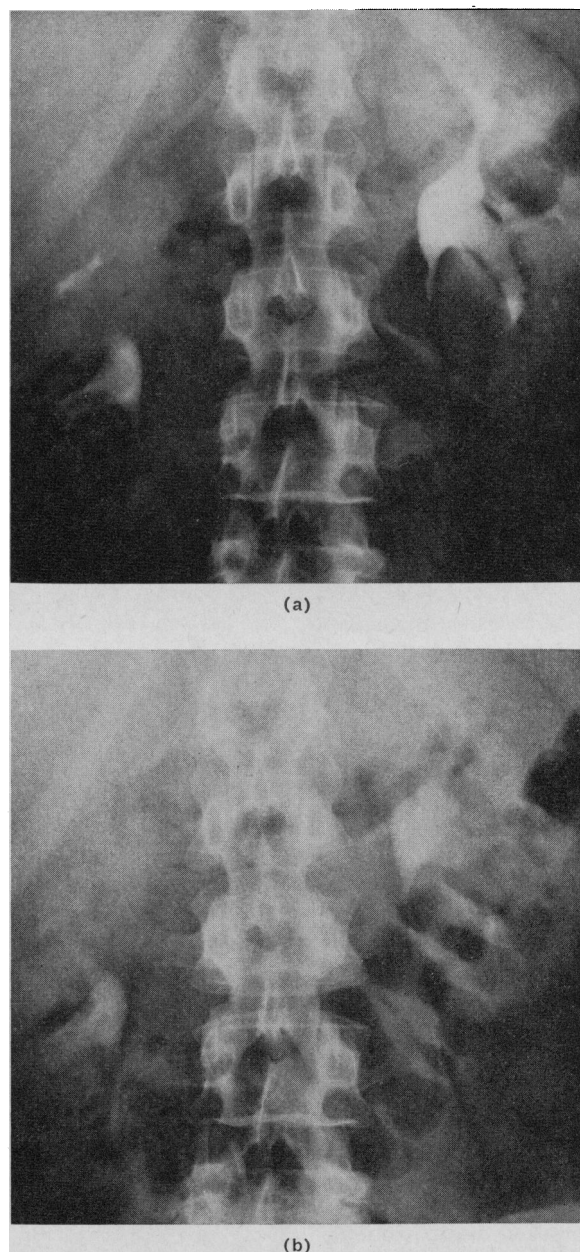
Bilateral positive UWT: (a) Radiograph taken at start of the urea infusion. (b) Lack of washout bilaterally at 42 minutes after start of urea infusion. This patient with clinical lupus erythematosus was found at necropsy to have severe atrial nephrosclerosis.
